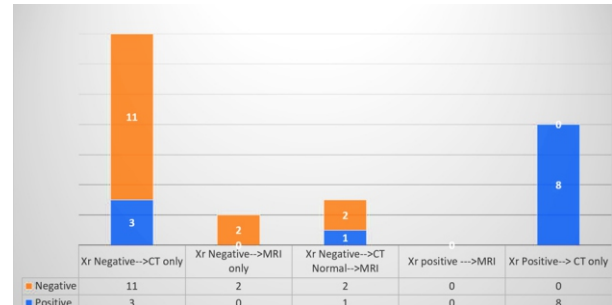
Further imaging relative to X-ray finding
